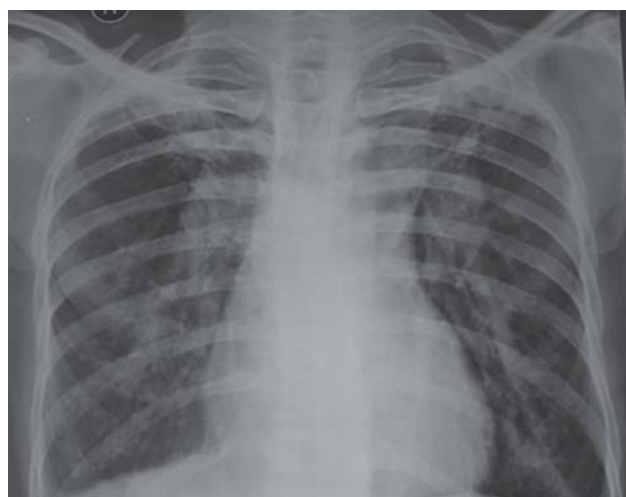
Chest radiograph (postero-anterior view) showing bilateral upper zone diffuse fibrosis with both hila prominent and shifted upwards.
